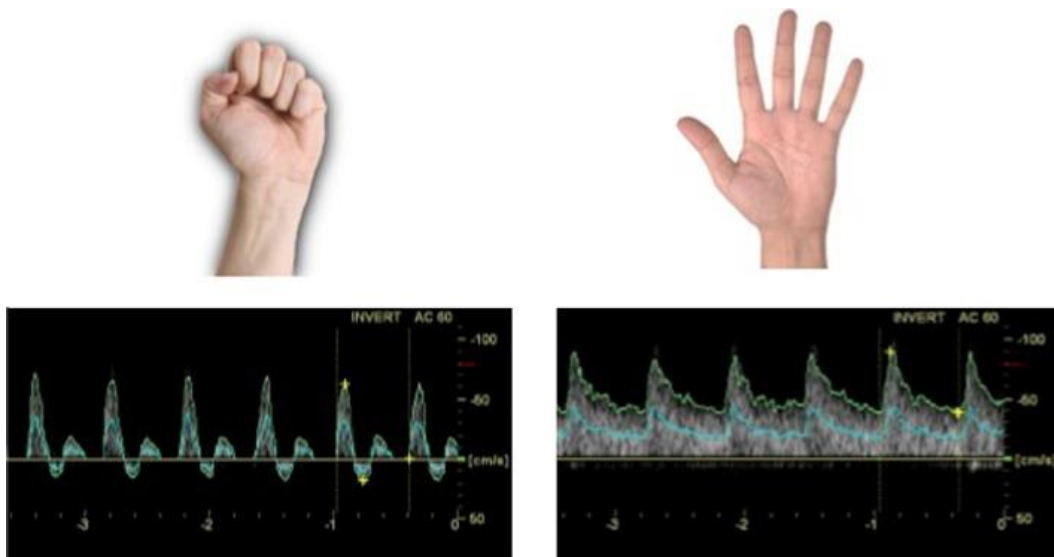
Test for reactive hyperemia. *Right:* Doppler spectrum during the reactive hyperemia phase with the hand opened, *left:* Ischemia phase with fist closed and matching Doppler spectrum.⁵⁷
